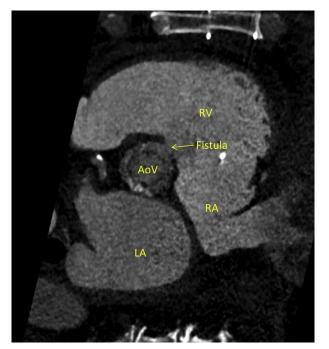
Retrospectively gated, dual-source cardiac CT scan showing fistulous communication between the right sinus of Valsalva and the right ventricle. *AoV*, Aortic valve; *LA*, left atrium; *RA*, right atrium; *RV*, right ventricle.
